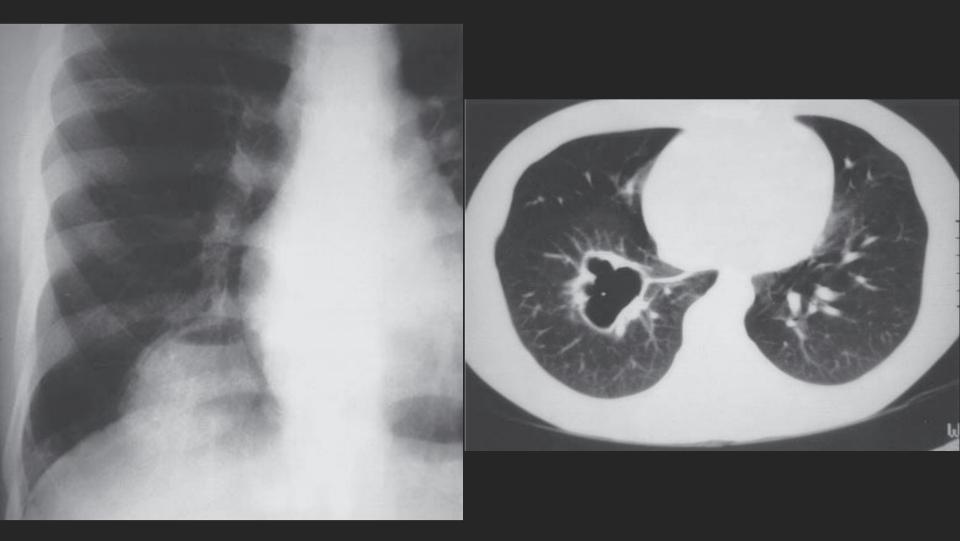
Infected intrapulmonary bronchogenic cyst in a child. A, Frontal and B, lateral chest radiographs show a large right-sided intrapulmonary mass with an air-fluid level. The cyst wall is thickened by inflammation.
